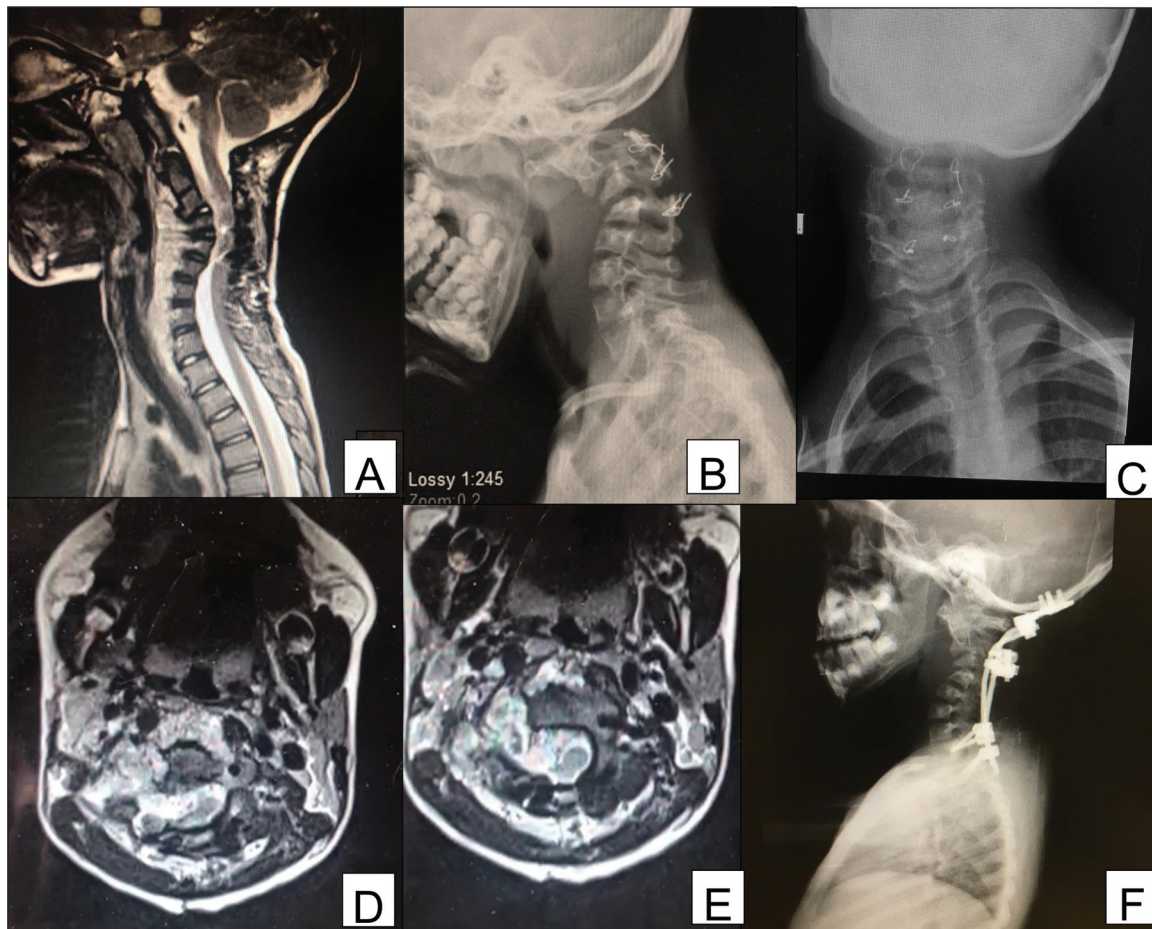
A 6 year-old boy who underwent a previous C2-3-4 laminoplasty for resection of an intradural neurofibroma developed postoperative cervical kyphosis, with important pain and difficulty in swallowing, as shown in (A) the sagittal cervical magnetic resonance imaging (MRI) scan in T2-weighted sequence, and (B) in lateral and (C) anteroposterior plain cervical radiographs. Since the patient also had a giant anterior cervical neurofibroma, as shown in (A) and in (D, E) – axial T2-weighted sequence cervical MRI, the option of an anterior cervical surgery with tumor resection was refused by his parents due to the need of postoperative tracheostomy. We opted for preoperative traction using progressive adjustments of a halo vest for six weeks, followed by posterior occipito-cervico-thoracic fusion, because the lateral masses were too small and dysplastic for screw fixation. The patient presented persistent residual segmental kyphosis but with a good and acceptable head position after surgery, with significant improvement in symptoms.
